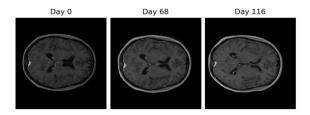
Sample MRI scan over time period
